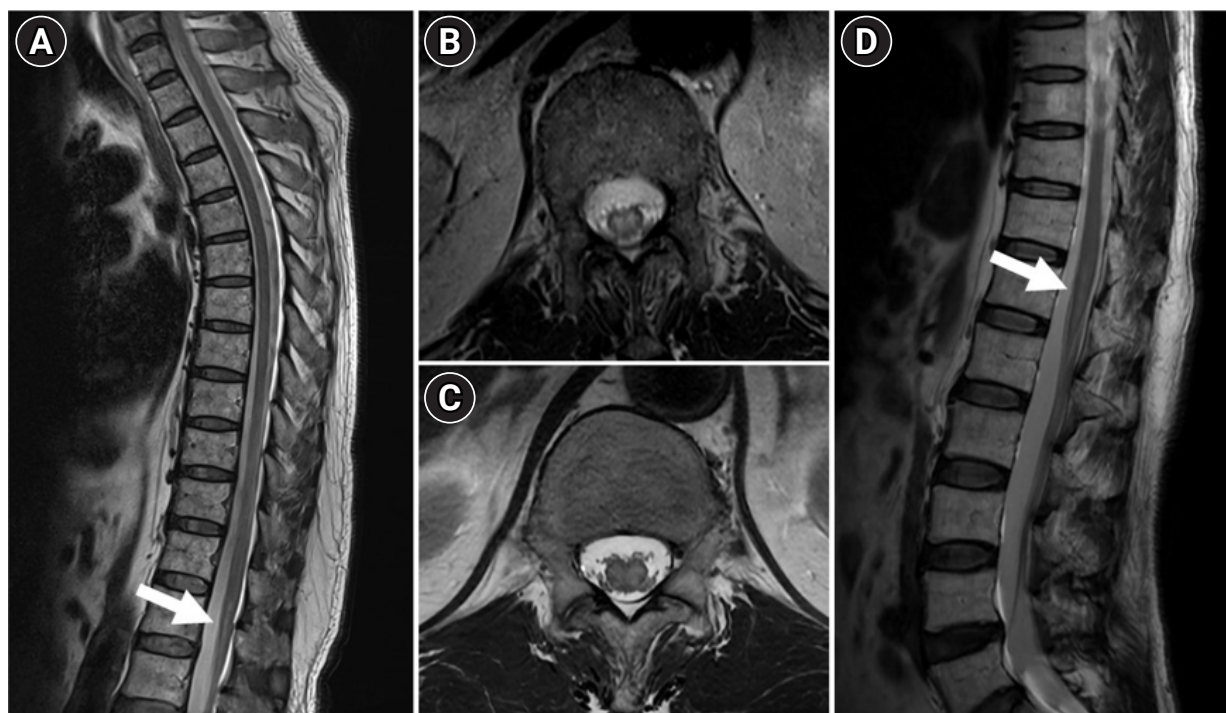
Magnetic resonance images of the patients. (A) High signal intensity was observed at the distal end of the spinal cord (conus medullaris) in patient 1 (arrow). (B, C) Axial images of the conus medullaris in patients 1 (B) and 2 (C) demonstrated diffusely increased signal intensities. (D) High signal intensity at the conus medullaris was highlighted in patient 2 (arrow).
